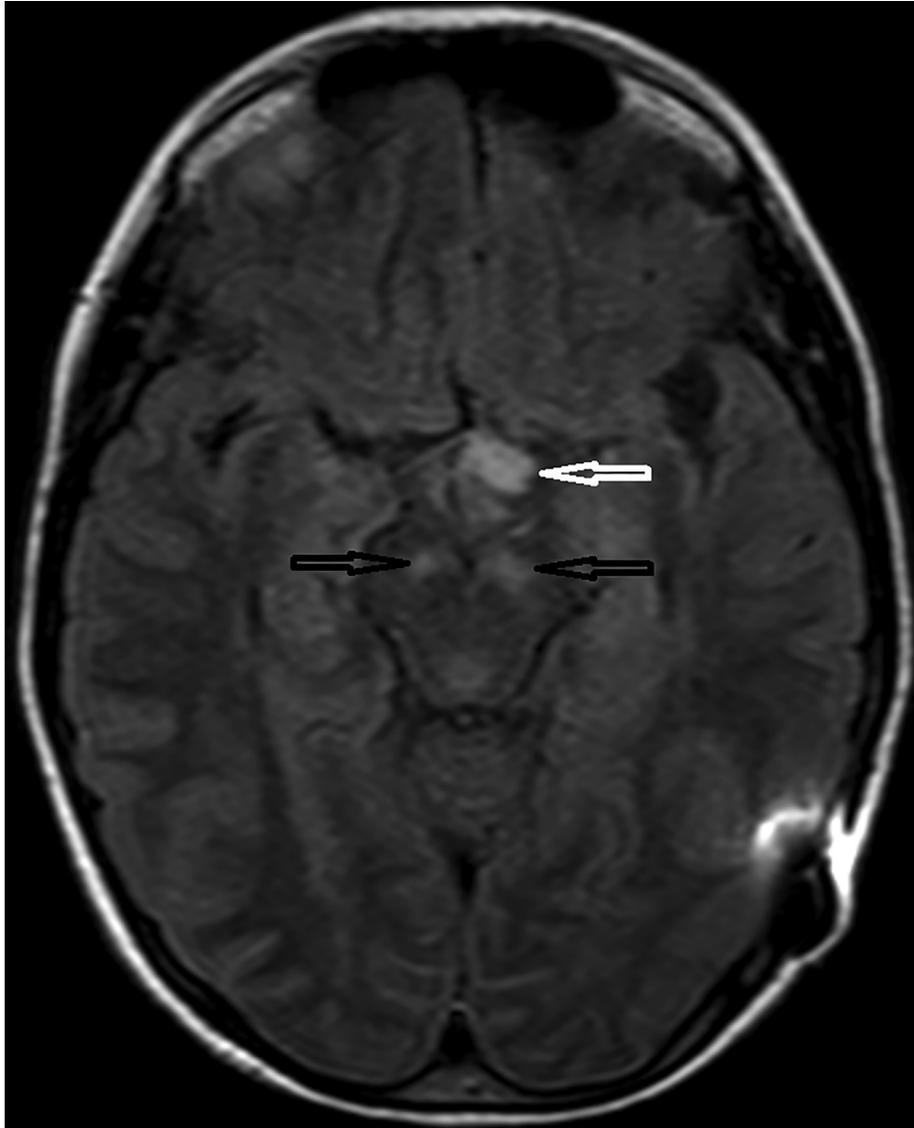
FLAIR in axial plane, hypothalamic GOOP has increased signal (white arrow), mesencephalic FASI (black arrows) have also increased signal.
